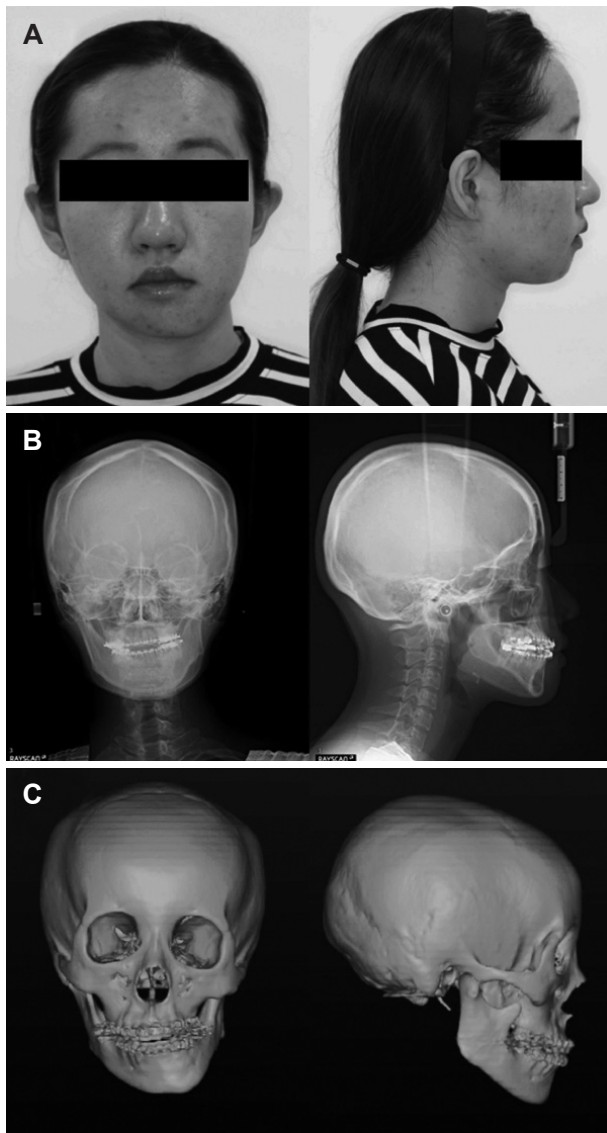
19Y 5M female with facial asymmetry before treatment (A) Facial photographs (B) Cephalometric radiographs (C) 3D virtual skulls.
